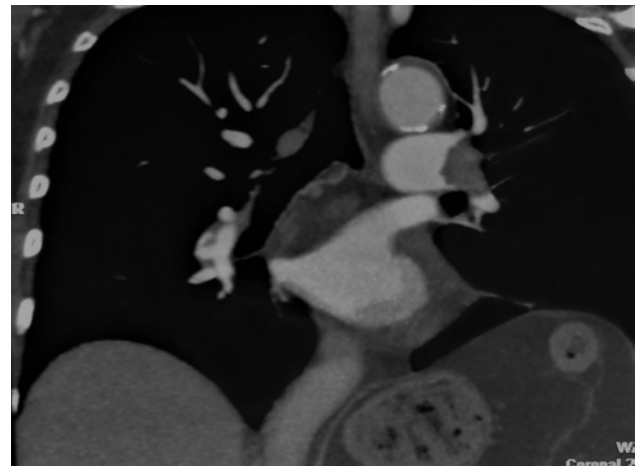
Computed tomography pulmonary angiogram (CTPA) in coronal plane shows a small reduction of the thrombotic mass in the left pulmonary artery.
